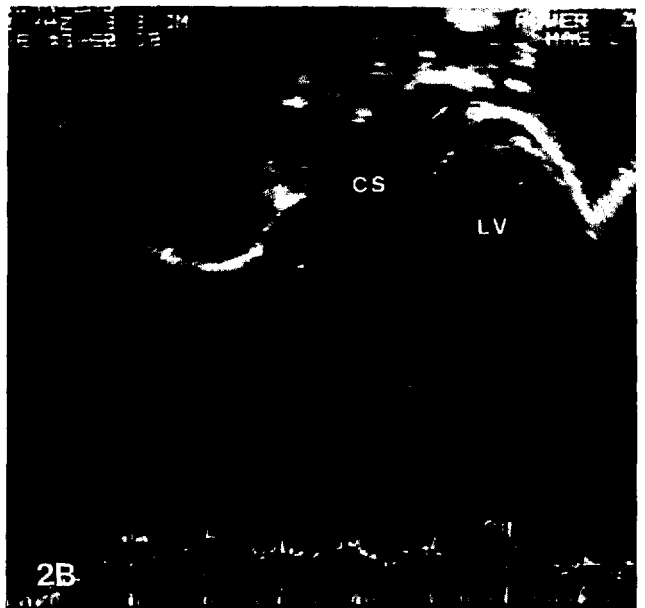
(A) Subxiphoid long-axis echocardiogram with more posterior angulation than used in Fig. 1A demonstrating a greatly enlarged coronary sinus (*CS*) draining into the right atrium (*RA*). *AC*, accessory chamber. (B) With additional posterior angulation, a left pulmonary vein (*arrow*) draining into the dilated coronary sinus (*CS*) is visualized. *LV*, left ventricle.
